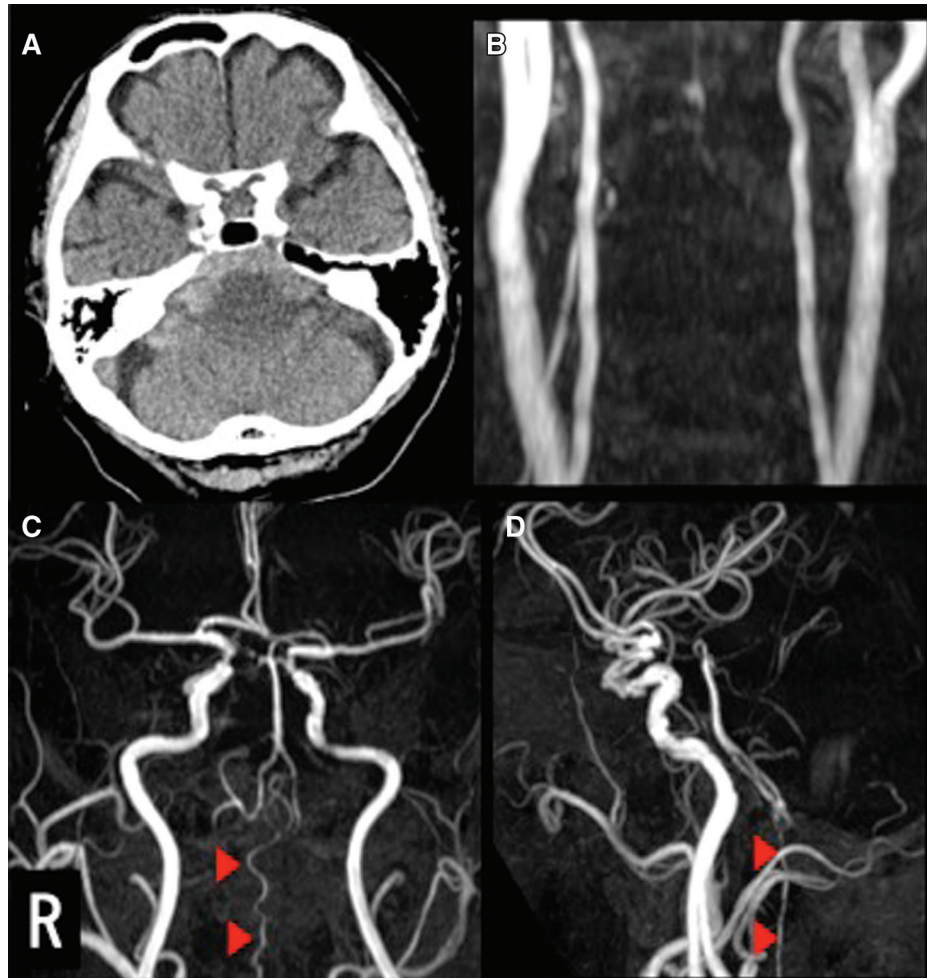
(A) CT revealed subarachnoid hemorrhage, mainly in the posterior fossa. (B, C, D) Cervical MRA (B) and brain MRA (C, anterior view; D, lateral view) showed occlusion of the bilateral VA and collateral flow signal via the ASA (arrowhead). ASA: anterior spinal artery; CT: computed tomography; MRA: magnetic resonance imaging; VA: vertebral artery
